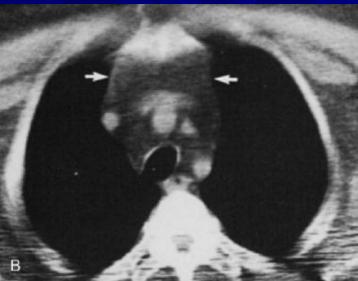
CT scan (B) showing the superior aspect of the mediastinum in a patient with mediastinal lipomatosis, appearing on standard chest roentgenogram (A) as diffuse mediastinal widening. The low radiographic density of fat (arrows) evident on the CT scan is pathognomonic. (Reproduced with permission from Shepard JG: Computed tomography of the mediastinum. Clin Chest Med 5:291–305, 1984.)
